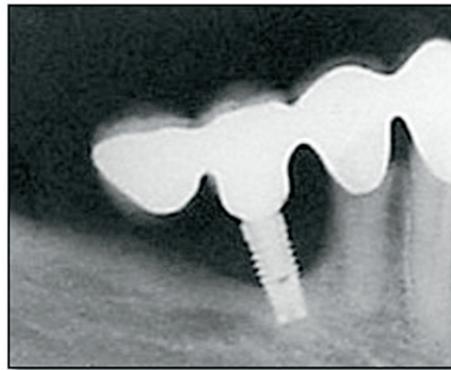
Radiographic aspect of the peri-implant bone loss.
